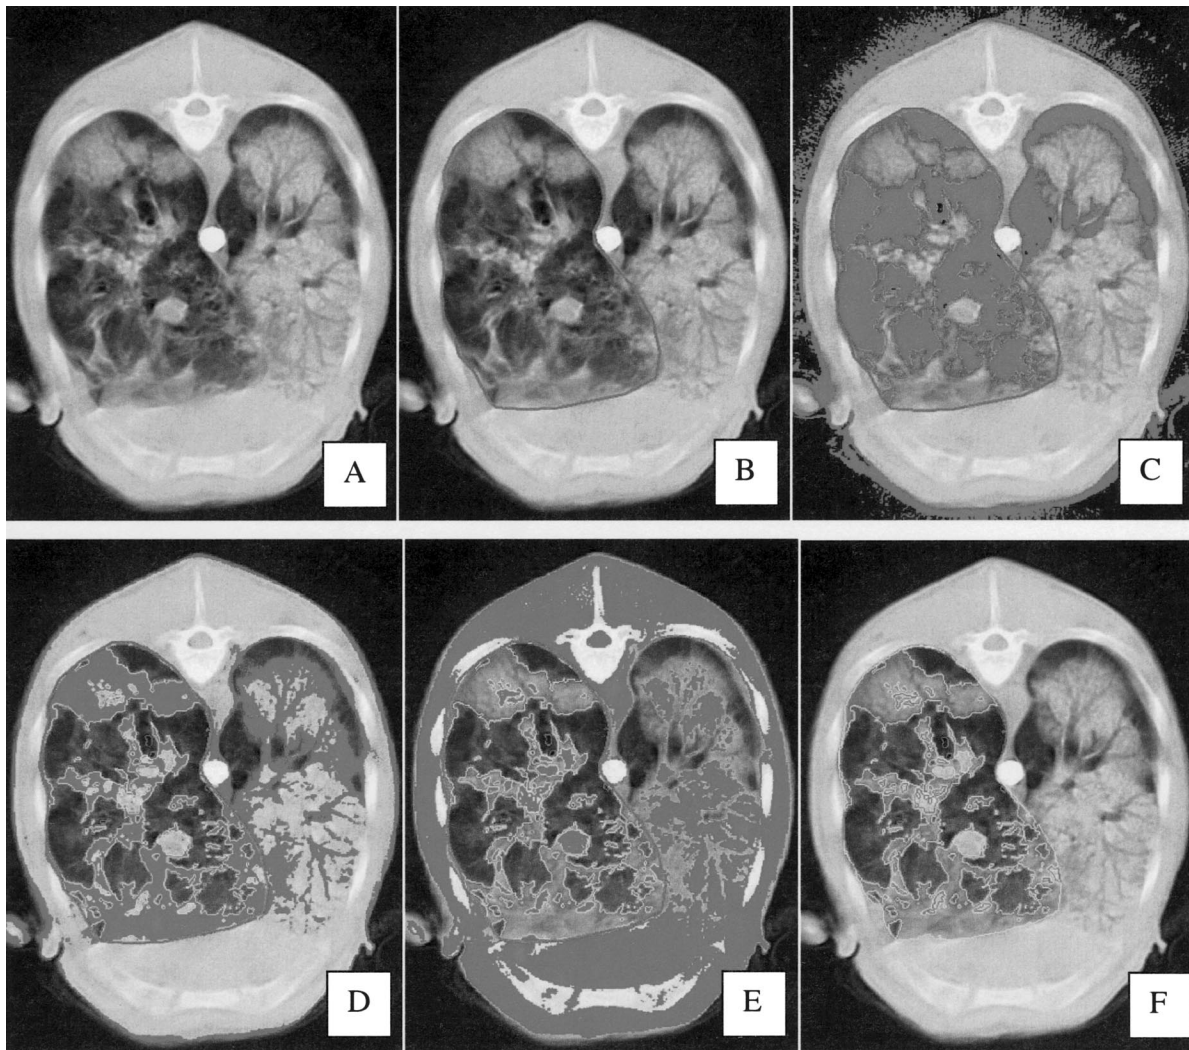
Method of semiautomated CT scan analysis. (A) Original CT scan. (B) Manual selection of the region of interest, in this case the right lung. All subsequent analysis will be confined to this region. (C) Identification of pixels in the normally aerated HU range. (D) Identification of pixels in the poorly aerated HU range. (E) Identification of pixels in the nonaerated HU range. (F) Final appearance of scan. Hyperinflated areas, although present, occupied an insignificant percentage of the total lung volume in this study and are not shown.
